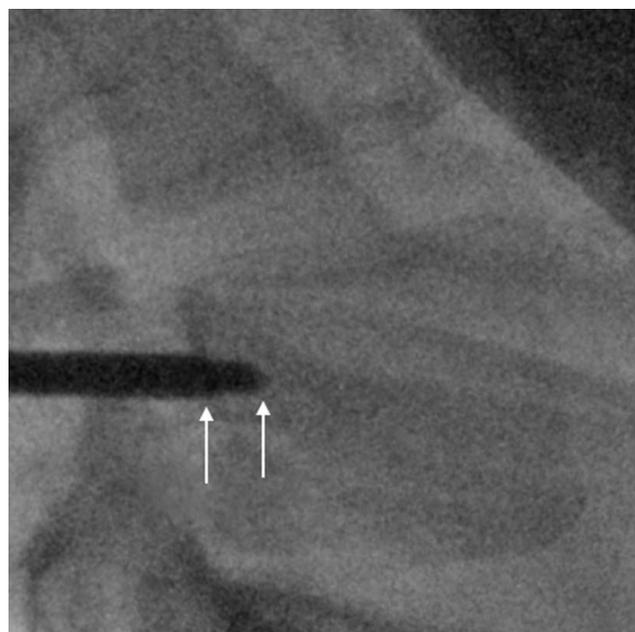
Lateral x-ray at L5 showing the endpoint of the ICA with the tip of the stylet and leading edge of the cannula in the vertebral body.
